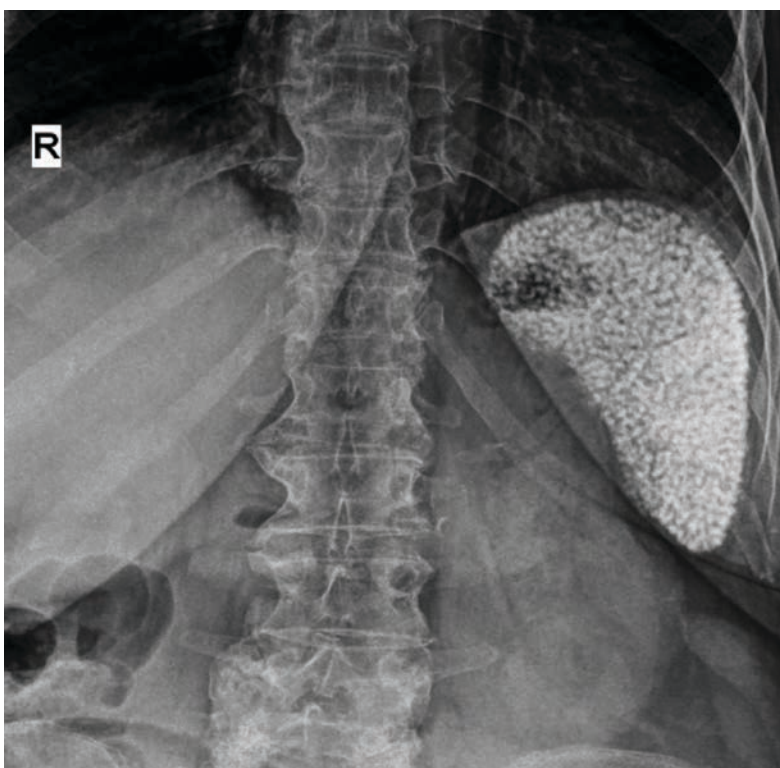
Chest X-ray - multiple splenic microcalcifications
